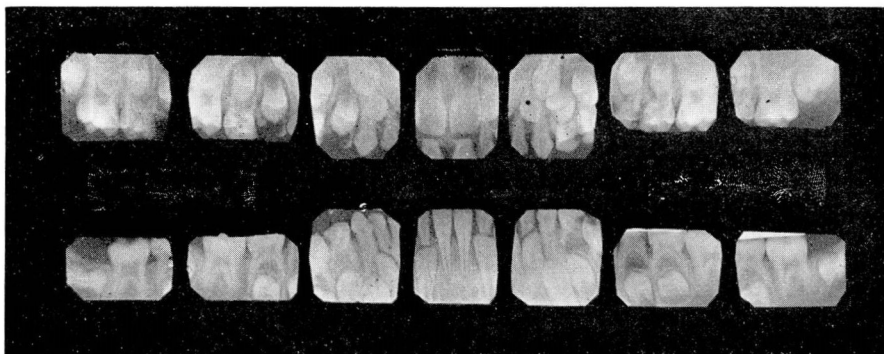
Roentgenograms of teeth of child aged 7.
